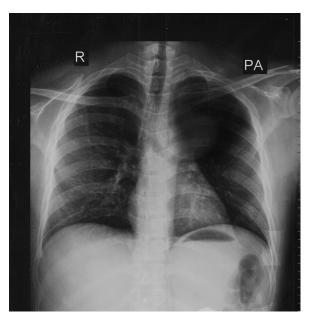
At 6 months post completion of treatment, the serial chest radiograph showed significant decrease in the size of the lesion
